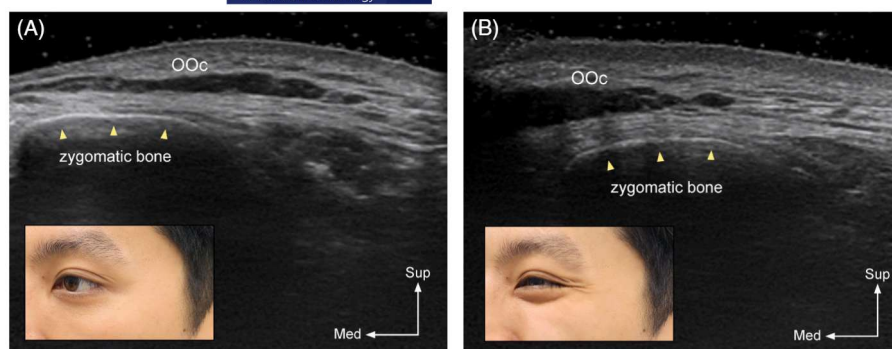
Dynamic ultrasonography performed during crow's feet formation. (A and B, ultrasound images taken while the face was relaxed and when crow's feet formed, respectively)
